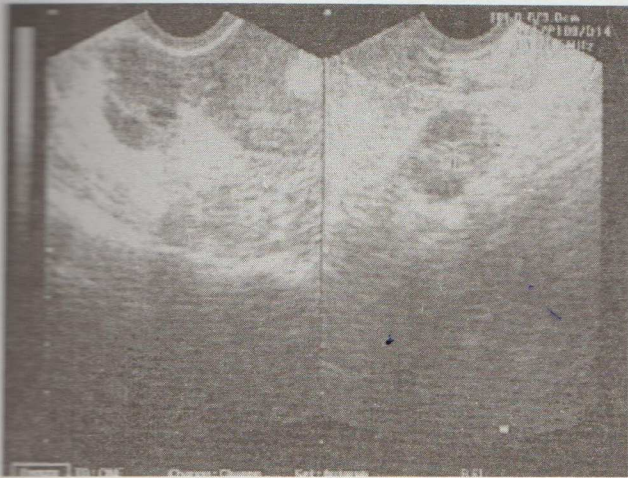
An ultrasound picture showing a thickened endometrium and polycystic ovaries.
